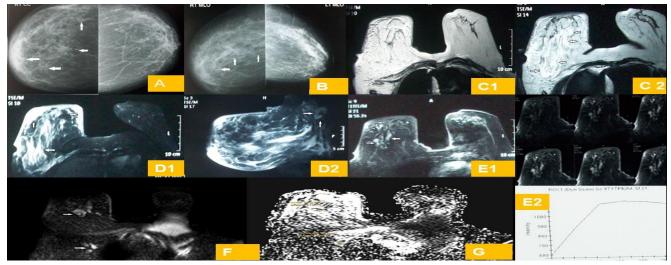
a 55 years old female patient presented with Rt. Breast redness, swelling & mastalgia. (A) & (B) mammographic CC & MLO views respectively show Rt. retroareolar and upper outer quadrant increased breast density denoting global asymmetry (Arrows), associated with mild skin thickening(.C1&C2) Axial T2 WI & (D1) axial T2 SPAIR show Rt. breast diffuse hyperintense SI extending to the right chest wall with skin thickening denoting interstitial edema (Arrows) (D2) Sagittal T2 SPAIR shows Rt. axillary enlarged lymph node with thick cortex (Arrows)(E1) Axial T1 post contrast with fat suppression shows Rt. upper outer area (arrows) of clumped non- mass like enhancement. (E2) Time intensity curve of the selected ROI demonstrates type II time intensity curve with fast initial enhancement & plateau delayed phase. (F) DWI & (G) ADC map demonstrate high DWI signal(arrows) & low ADC signal for both ROI (1) Rt. interstitial lesion & ROI (2) Rt. enlarged axillary lymph node indicating restricted diffusion.ADC values were 0.72 x 10⁻³ sec/mm² & 0.86 x 10⁻³ sec/mm² for both ROI (1) & (2) respectively. Diagnosis: Right Inflammatory carcinoma.
